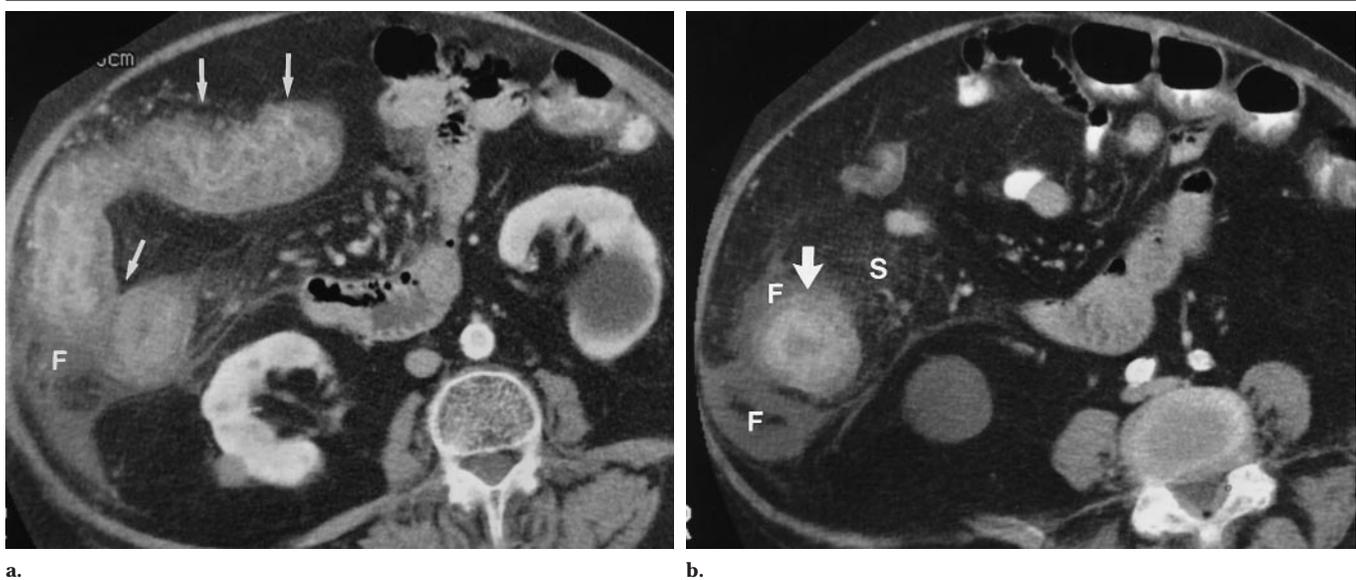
Ischemic colitis of right colon in an 83-year-old woman with a recent history of atrial fibrillation and a hypotensive episode, who presented with right lower quadrant pain and rectal bleeding. (a, b) Contrast-enhanced CT scans at two different levels show segmental distribution involving the entire ascending colon and hepatic flexure (arrows in a, arrow in b). Circumferential wall thickening and heterogeneous enhancement with layers of low and high attenuation are consistent with colonic edema. Right colon has a shaggy, wet appearance with pericolic streakiness (S in b), pericolic fluid collections (F), and loss of haustra. Diagnosis was confirmed at colonoscopy, and ischemia resolved without complications with conservative therapy. Fluid-filled cysts are present in both kidneys.
